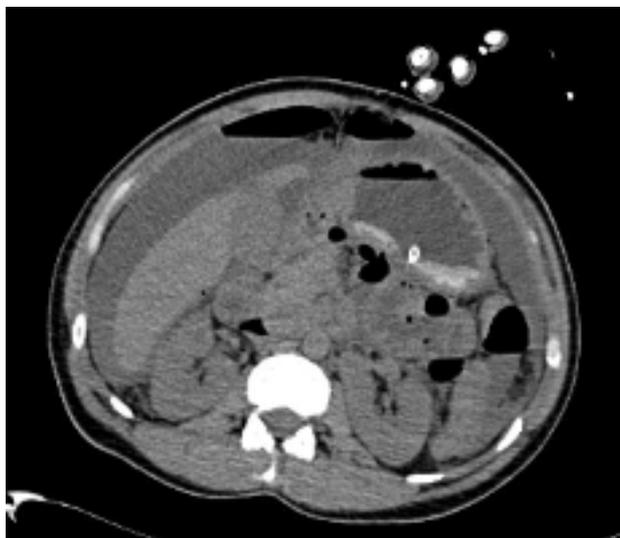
Non-contrast abdominal CT revealed widespread fluid-air (perforation) in the abdomen
